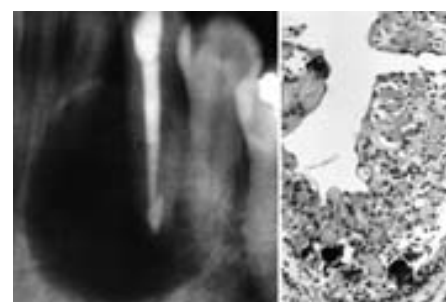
A persistent periapical radiolucency that upon biopsy (right) proved to be a calcifying odontogenic cyst. Note the typical keratinization (light globules) and calcification (dark globules) in the epithelial lining (courtesy of Dr. Timothy A. Wong, Sacramento, Calif.).
